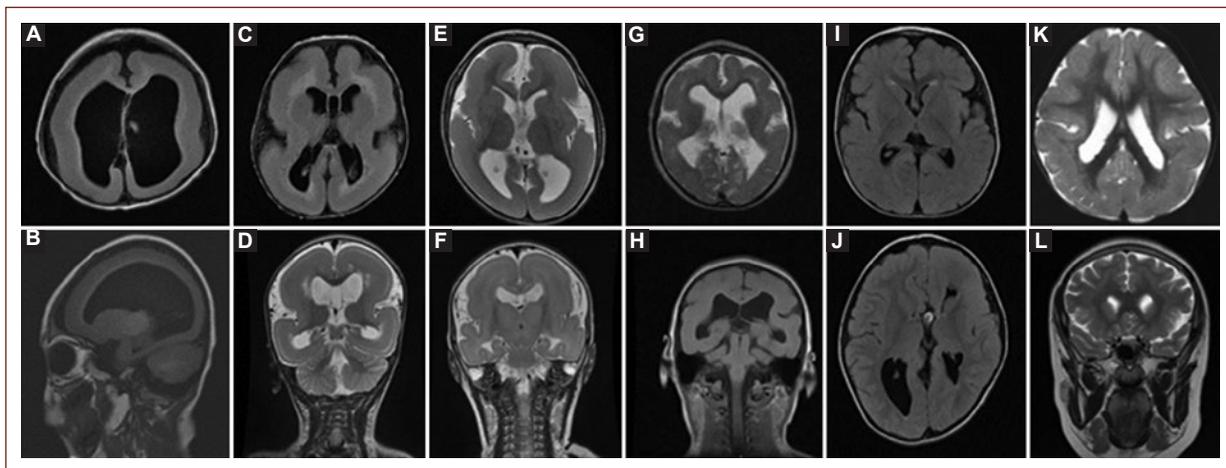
Brain MRI findings. A and B: agyria diffuse. C-F: agyria diffuse with few superficial undulations on frontal and temporal poles. G-H: agyria and pachygyria mixed, with frontal pachygyria and parieto-occipital agyria. I-J: partial pachygyria more severe anterior. K: more severe partial pachygyria posterior. L: heterotopia in subcortical band.
